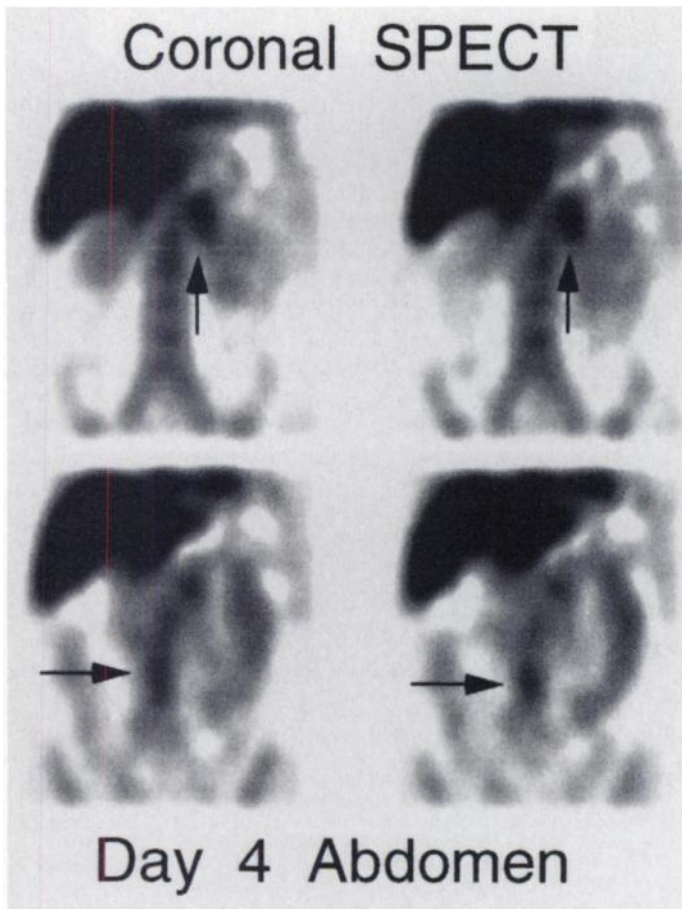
Day 4 coronal SPECT images of the abdomen. Arrows in the two lower images point to localization in lymph nodes near the aortic bifurcation. Arrows in the upper two images point to uptake in lymph nodes in the periaortic area just left of midline.
